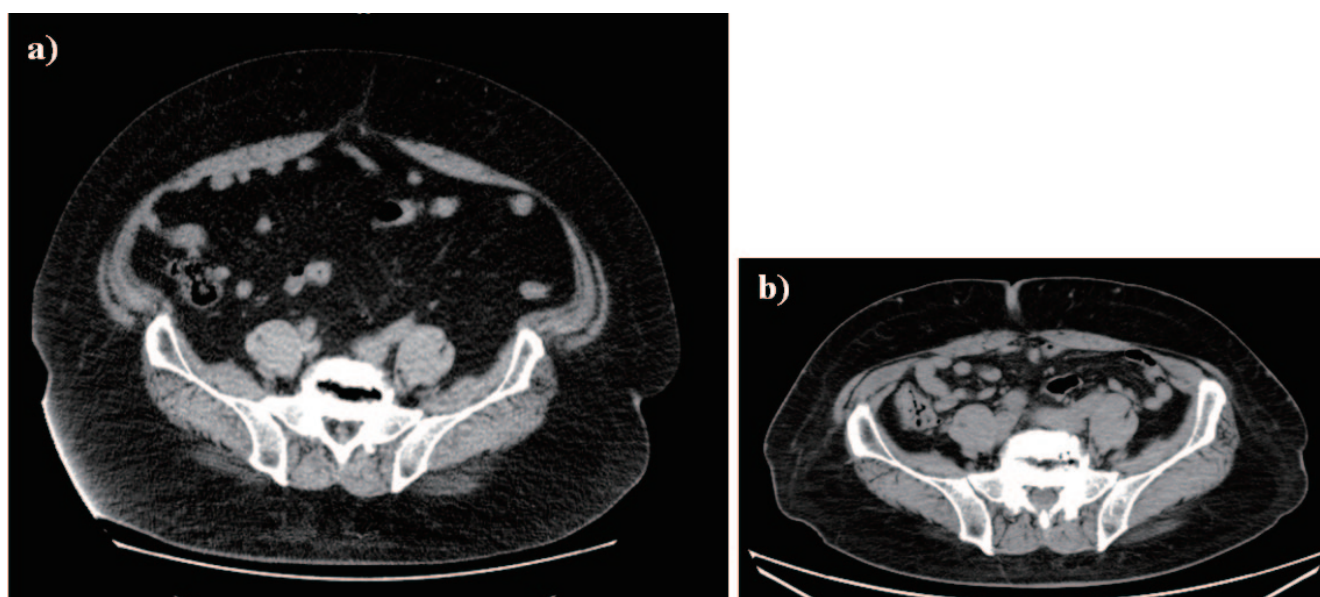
Abdominal computed tomography.
